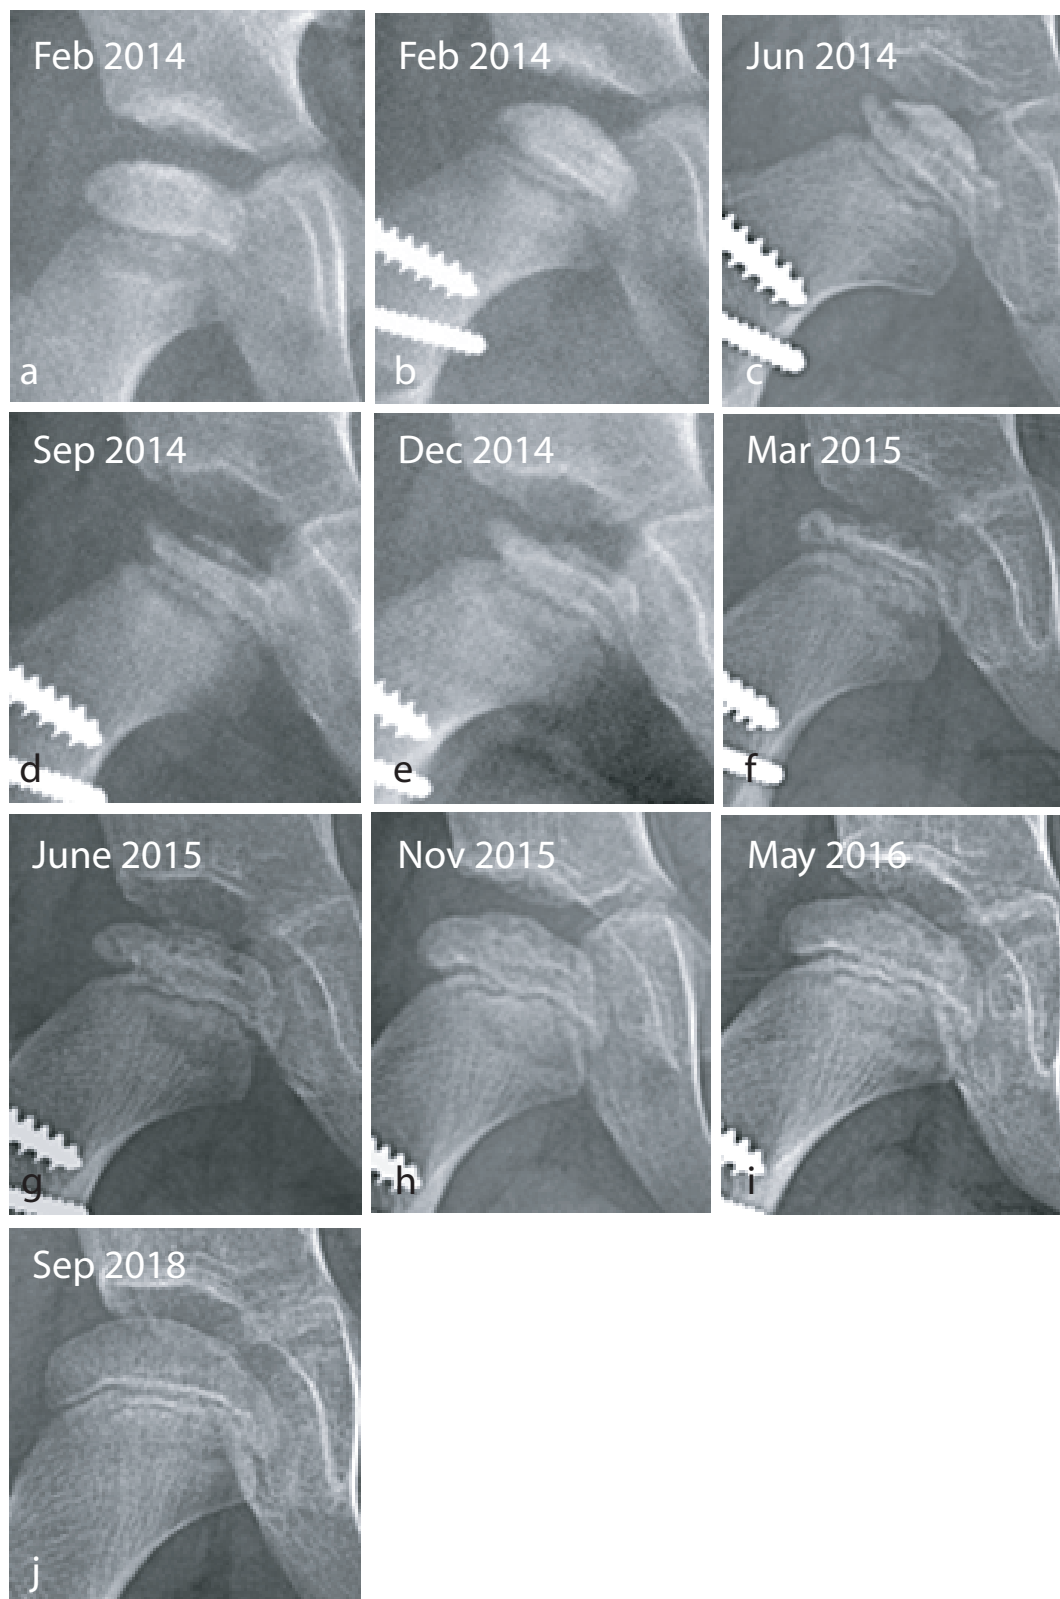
Sequential radiographs of a child who underwent proximal femoral varus osteotomy in stage Ib. A horizontal fissure extending across the entire width of the epiphysis appears parallel to the growth plate (c). Resorption of the superficial avascular fragment occurs progressively (d, e). New bone formation then proceeds from the deep surface of the horizontal fissure towards the articular surface (f) until the epiphysis is completely reconstituted (g-j).
